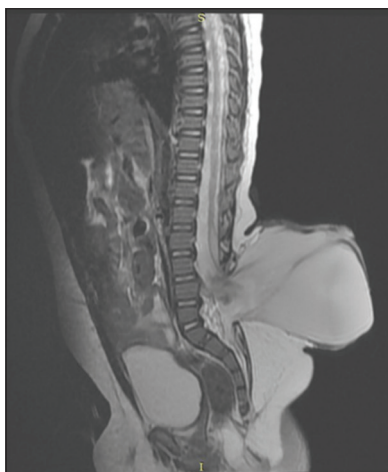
Magnetic resonance imaging spine image showing meningocele with tethered spinal cord
